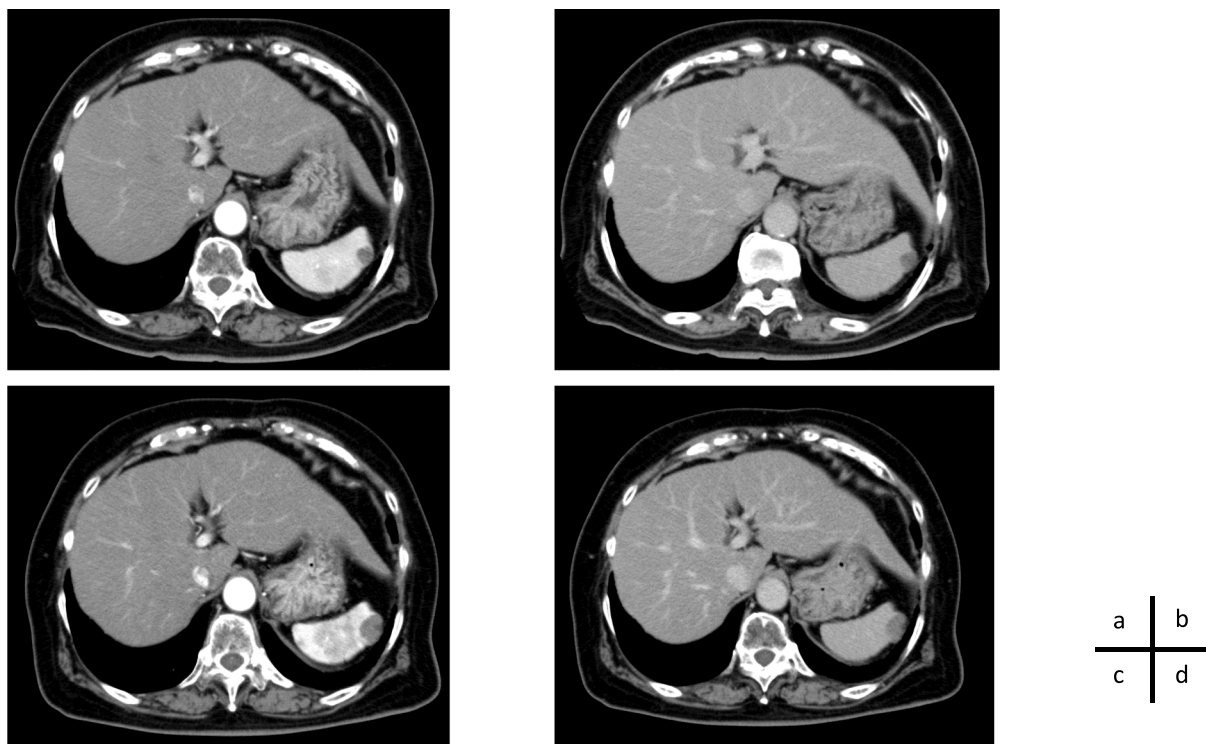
Contrast-enhanced CT scans obtained in case 1
